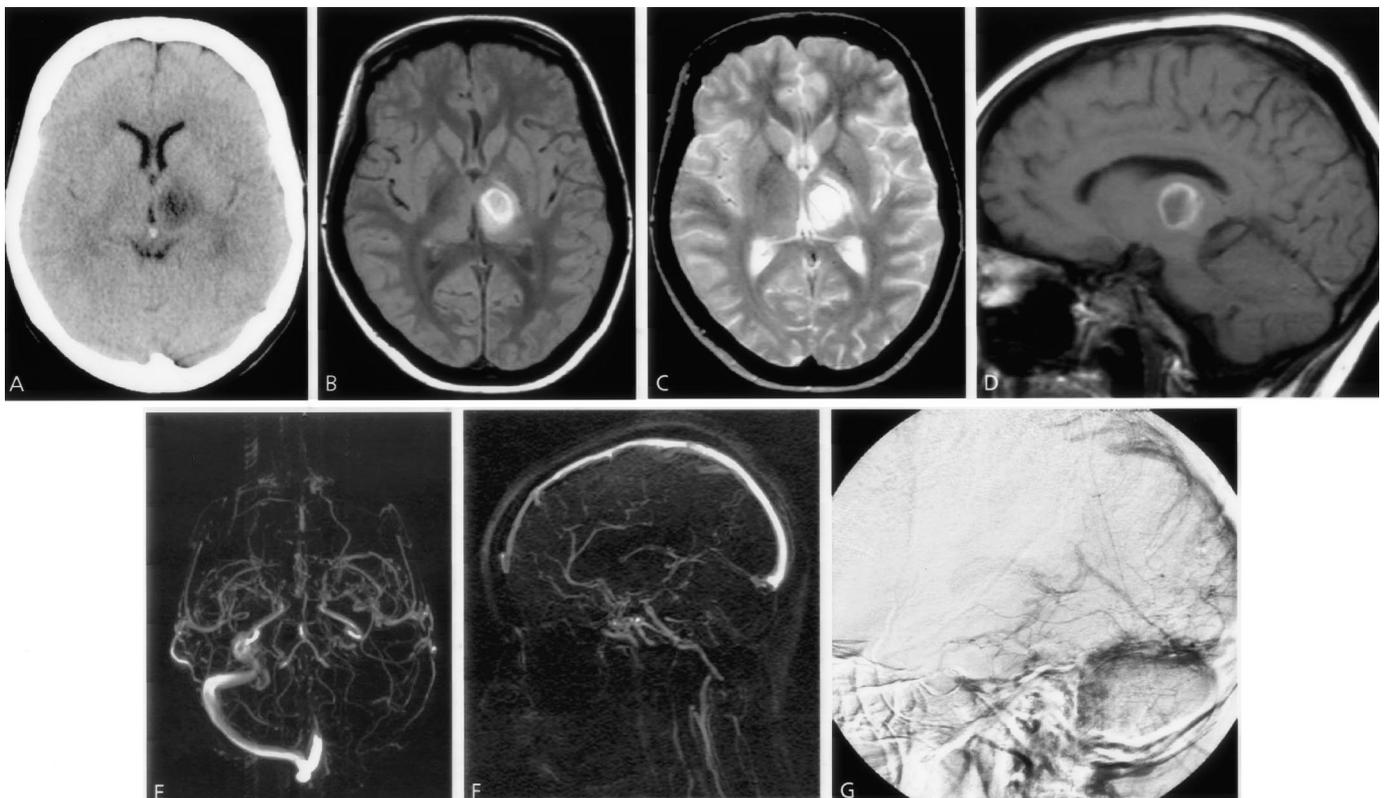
Case 2. (A) Brain CT showing a hypodense lesion in the left thalamic region. (B) Axial MRI FLAIR, (C) T2, and (D) T1 showing edema with a hemorrhagic component in the left thalamus. (E) Axial and (F) sagittal MR venography and (G) sagittal digital subtracted catheter angiography showing partial filling of the internal cerebral veins, basal veins, vein of Galen, and straight sinus. The left sigmoid and transverse sinuses are absent.
